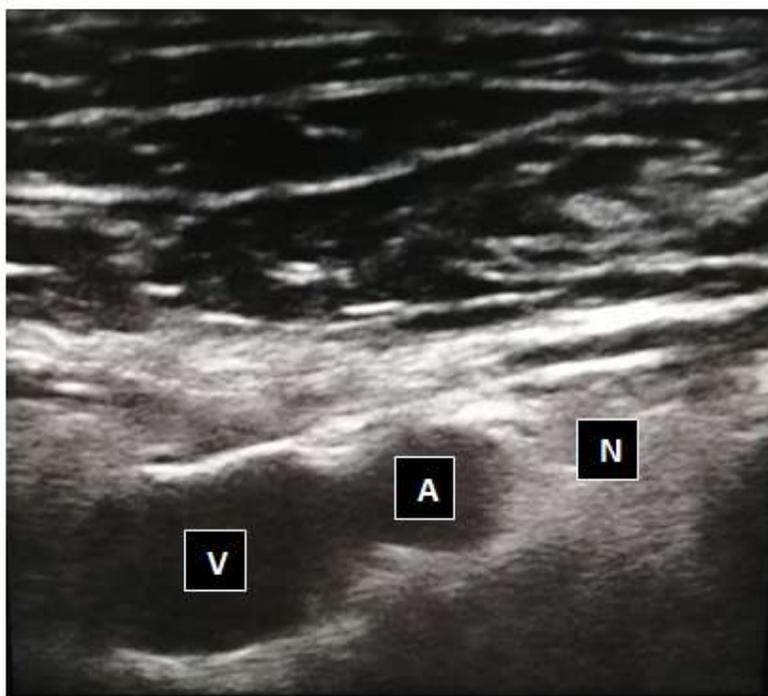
Femoral Artery (A), Vein (V) and Nerve (N) as seen on ultrasonography
